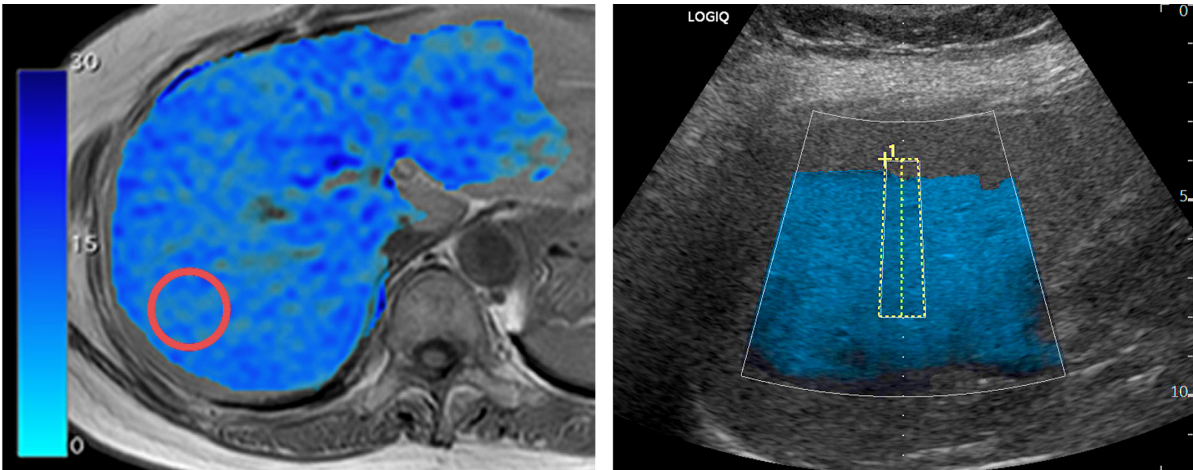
Region of interest (ROI) and attenuation map of (A) MRI-based proton density fat fraction (PDFF) and (B) Ultrasound-Guided Attenuation Parameter (UGAP) measurements.
